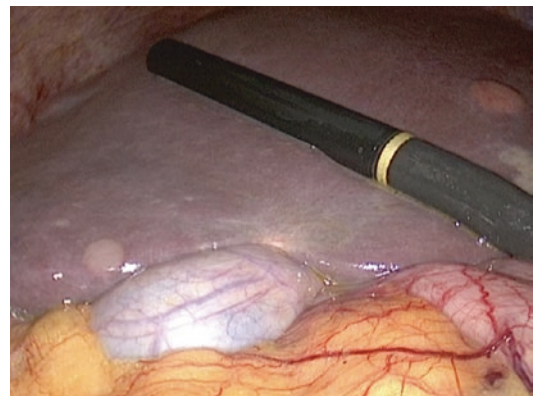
Intraoperative view of laparoscopic ultrasound evaluation in a case of multiple bilateral metastases
